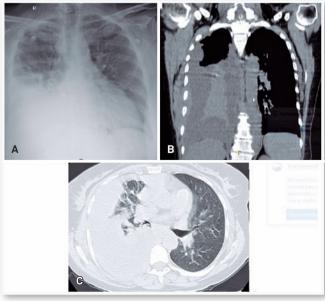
Massive pleural effusion (PE) on the right side, on X-Ray (A); the same PE seem in a coronal label (B) and transversal label (C) of computerized tomography.
